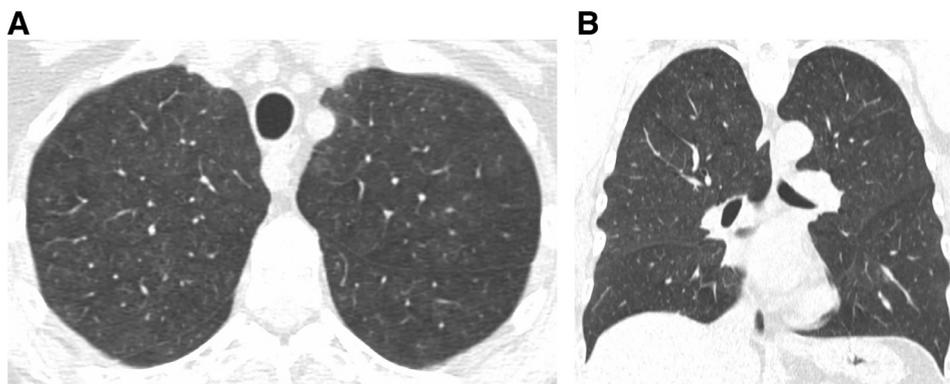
A 42-year-old asymptomatic female smoker with respiratory bronchiolitis. Axial (A) and coronal reformatted (B) CT images show mid and upper lung predominant centrilobular ground-glass nodules.
